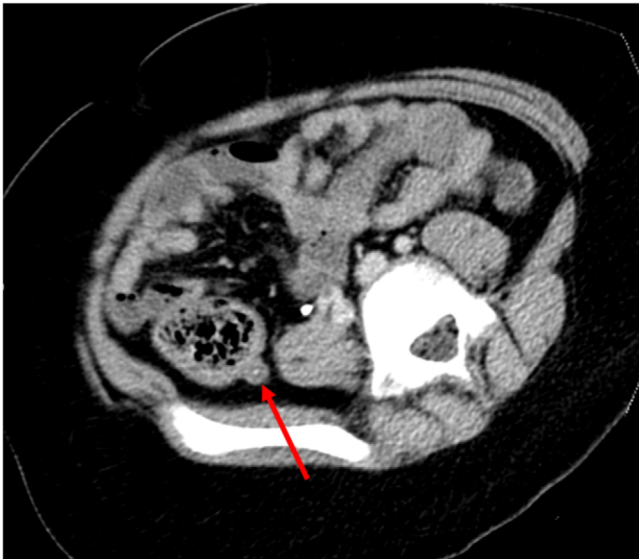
CT of abdomen in transverse view demonstrating the retrocecal appendix
